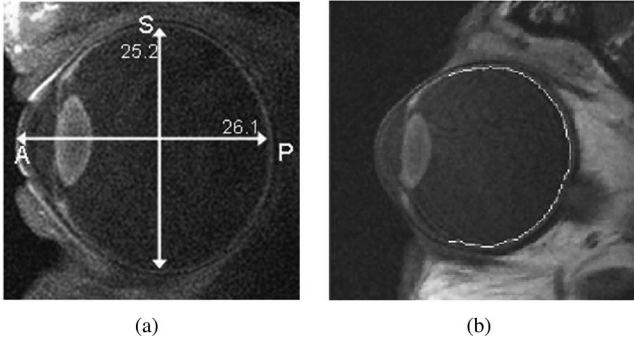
Biometric measurements from MRI images. (a) Axial length. (b) Retinal shape. (Reprinted with permission from ARVO.)
